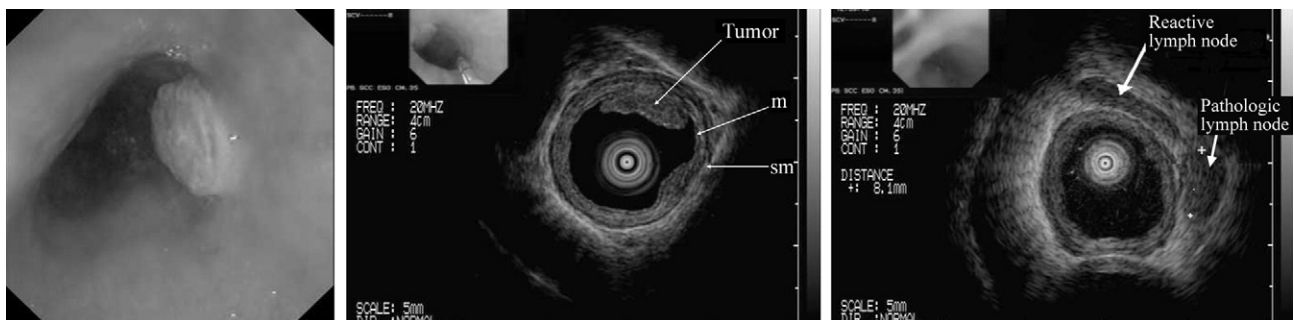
Early submucosal squamous carcinoma of the esophagus. Endoscopic view (left) shows nodule of the lower third of the esophagus (type 0-I). Endoscopic ultrasonography with 20-MHz miniprobe (center, right) shows mucosal and submucosal thickening. On pathologic examination (esophagectomy) it was a T1sm squamous carcinoma. One suspected (rounded shape, clearly defined margins, hypoechoogenicity) lymph node (arrow) for metastatic involvement; another, probably reactive (thick arrow). (m = mucosa; sm = submucosa.)
